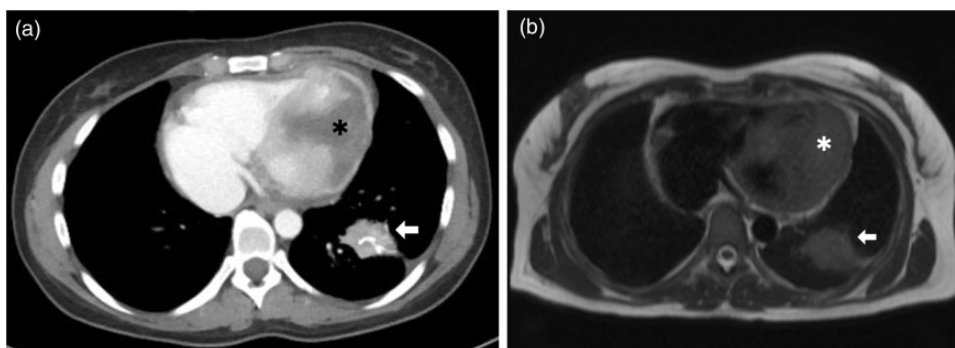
Pulmonary metastasis within the left lower lobe (white arrows): (a) axial contrast-enhanced CT scan, and (b) axial T1-weighted MR image. The black asterisk in (a) and white asterisk in (b) point to the cardiac metastasis.
